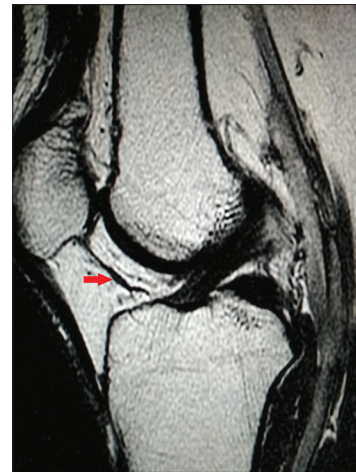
Sagittal T2-weighted image (3400/103) demonstrating a band-like hypointense structure (arrow) traversing through the infrapatellar fat pad consistent with a diagnosis of infrapatellar plica
